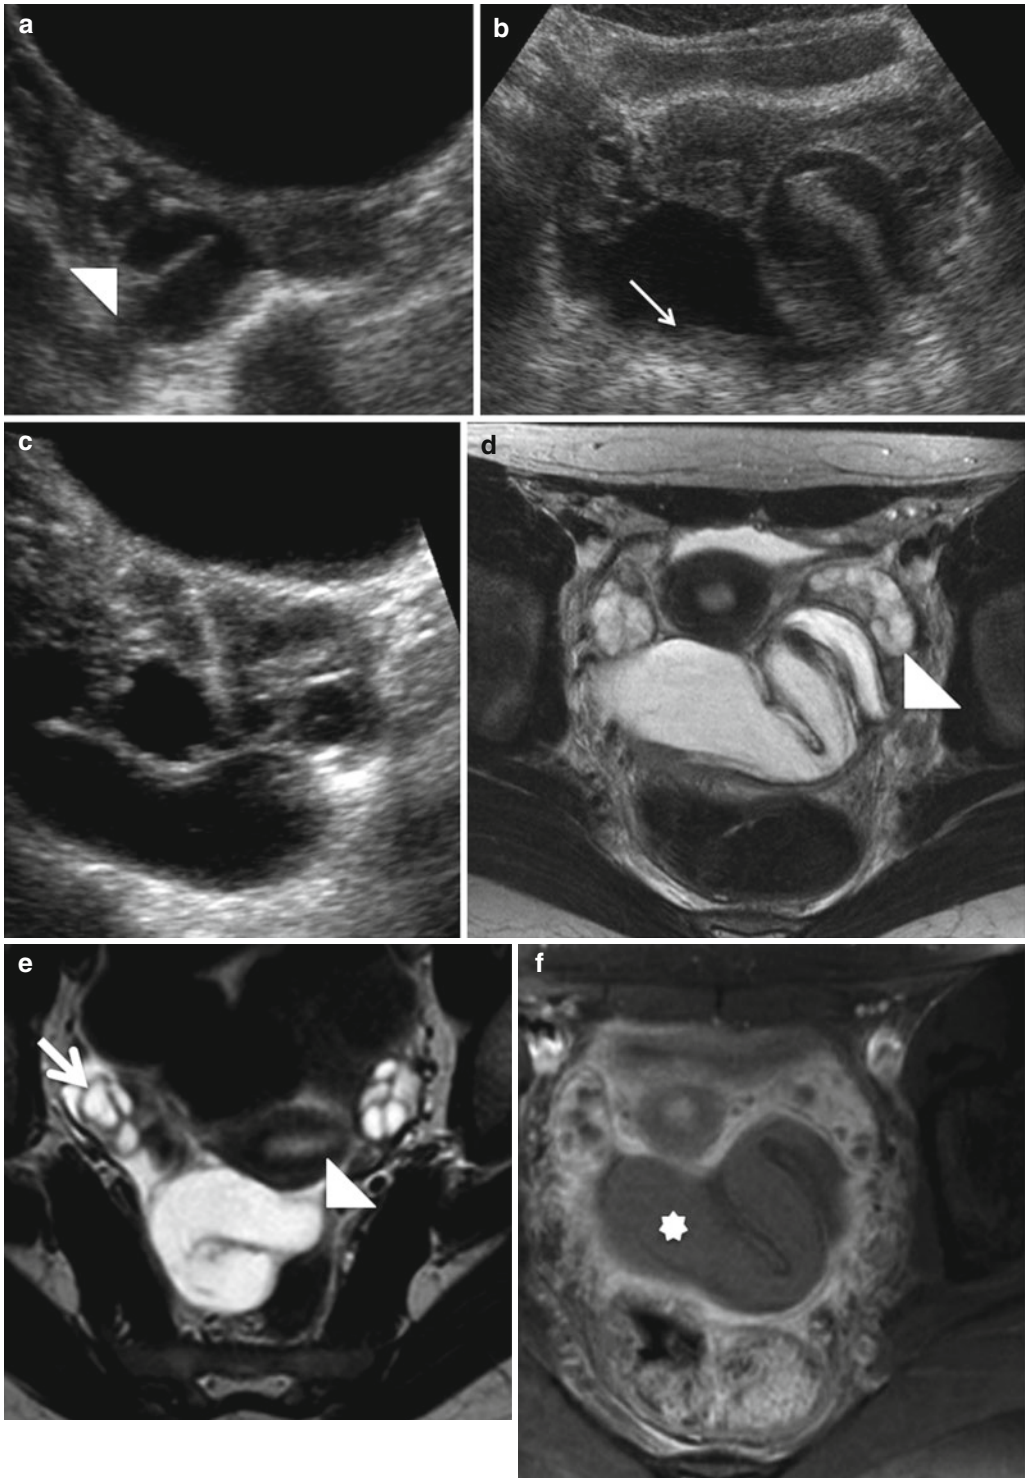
Isolated tubal torsion in a 12-year-old girl, 4 days after menarche. (a–c) US images show a dilated tubular structure with internal debris (arrow) and the beak sign (arrowhead). (d, e) Axial T2-weighted images show
